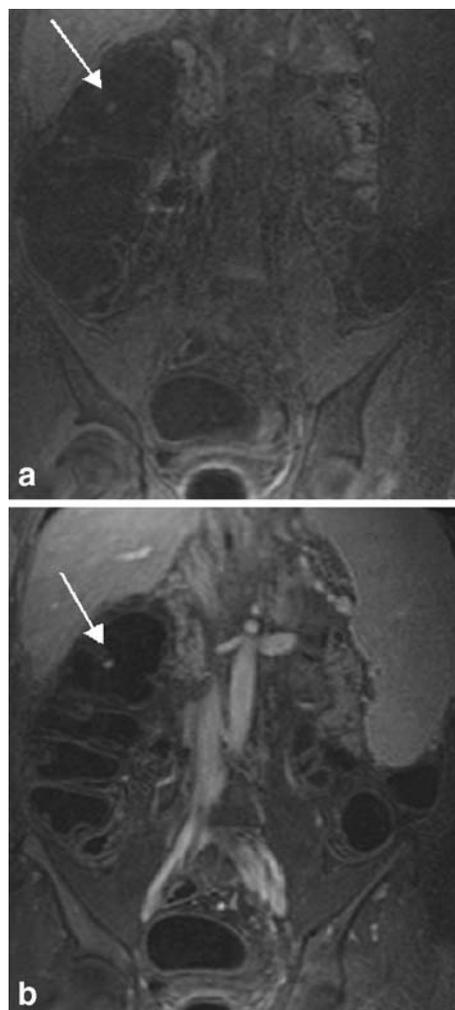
a Coronal MR source image from a 59-year-old man with known liver cirrhosis who underwent MRC due to positive hemocult test and suspected diverticulitis. On the coronal T1-weighted pre-contrast phase a hypointense lesion (*arrow*) is shown in the ascending colon. b Dark lumen MRC after intravenous injection of paramagnetic contrast. The coronal source image shows a contrast-uptake within the lesion. Conventional colonoscopy confirmed the presence of an ascending polyp (*arrow*)
